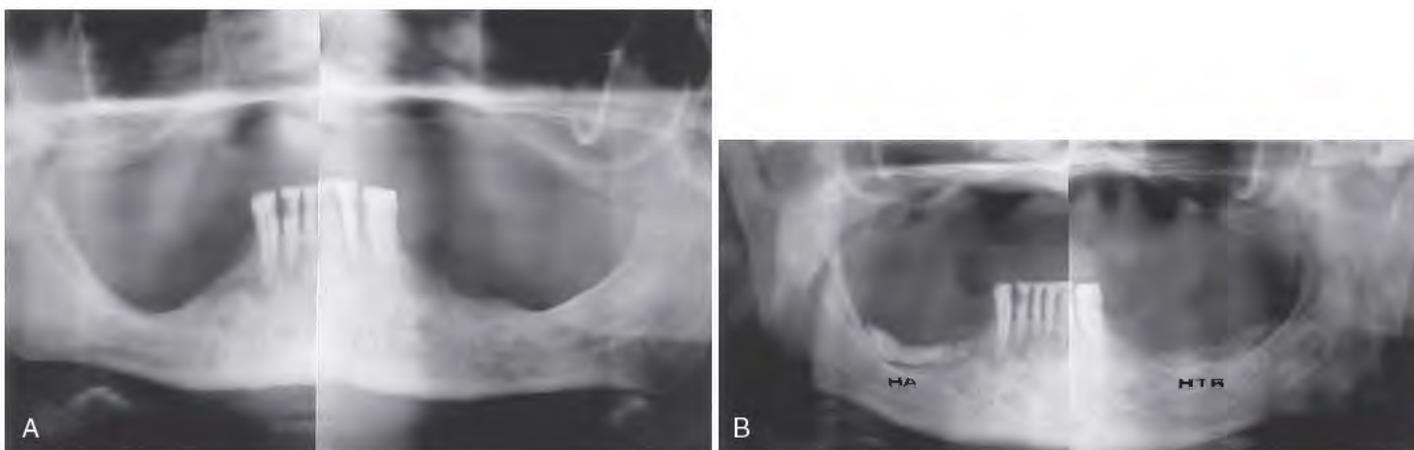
A, The preoperative radiograph of this mandible with posterior ridge atrophy shows a significant need for augmentation. B, The ridges are augmented by tunneling, and two different but equally effective grafting materials are used. The difference in radiodensity does not reflect their stability or competence.
